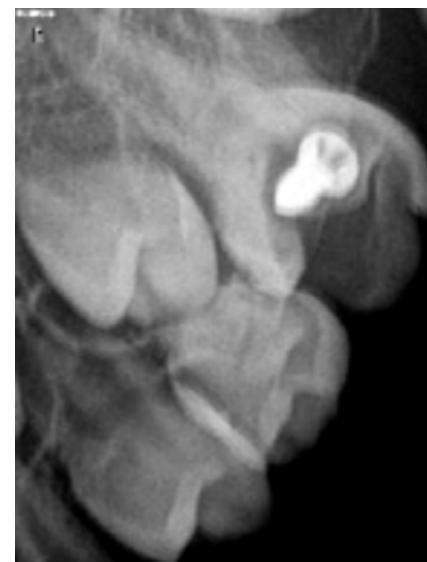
Intra-oral peri-apical radiograph showing a cylindrical foreign object packed tightly in the tooth.
